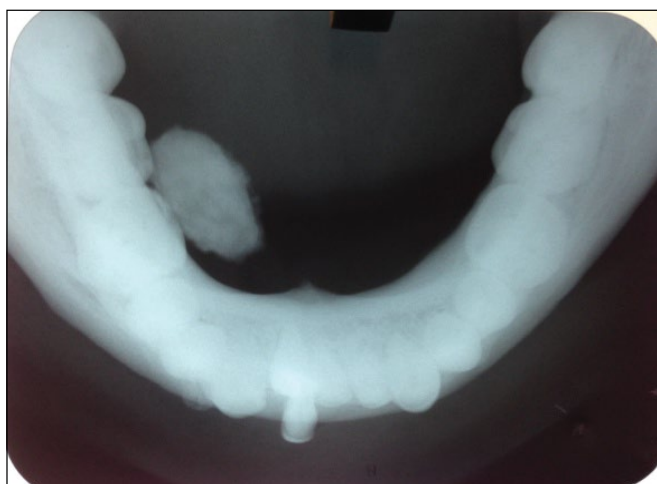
Trans-occlusal radiograph showing sialolith in the right body of mandible).
